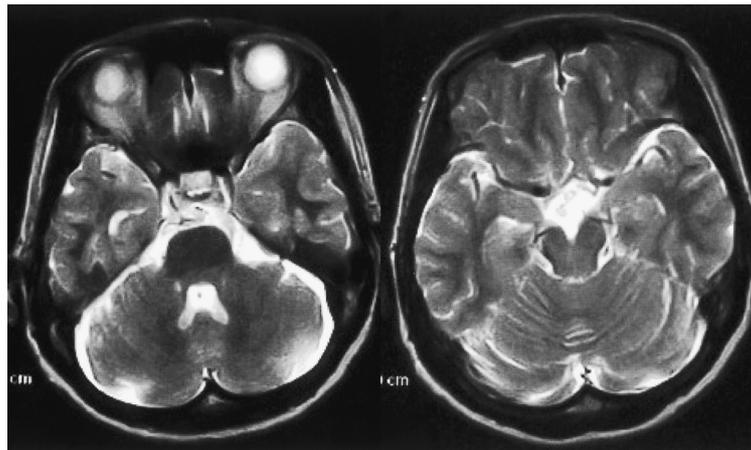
The magnetic resonance imaging (T2-weighted images) findings indicated no ischemic change in the brain parenchyma. In addition, the main vascular luminal visualizations could be identified.
